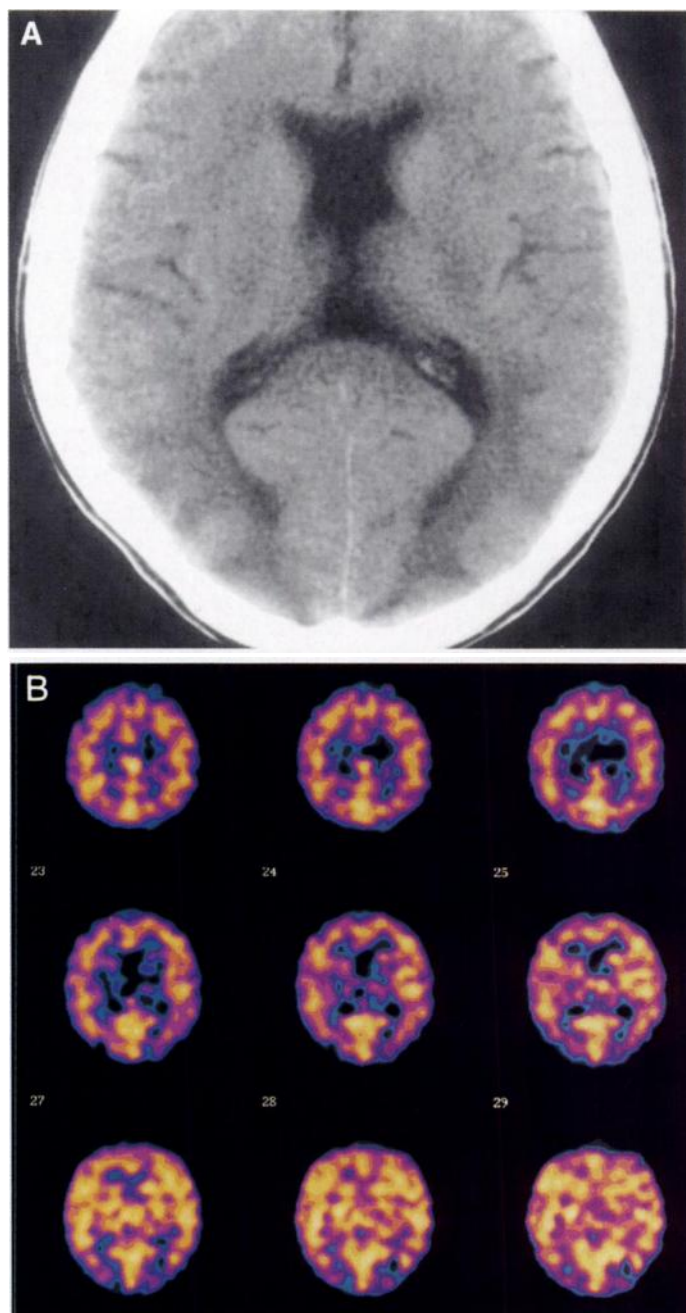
(A) Noncontrast CT performed 2 wk later reveals only minimal resolution of white matter abnormality in parieto-occipital area. (B) Representative transaxial slices from the follow-up ^{99m}Tc -HMPAO study show almost complete resolution of the previous abnormalities with only mildly reduced perfusion in the left occipital lobe.
